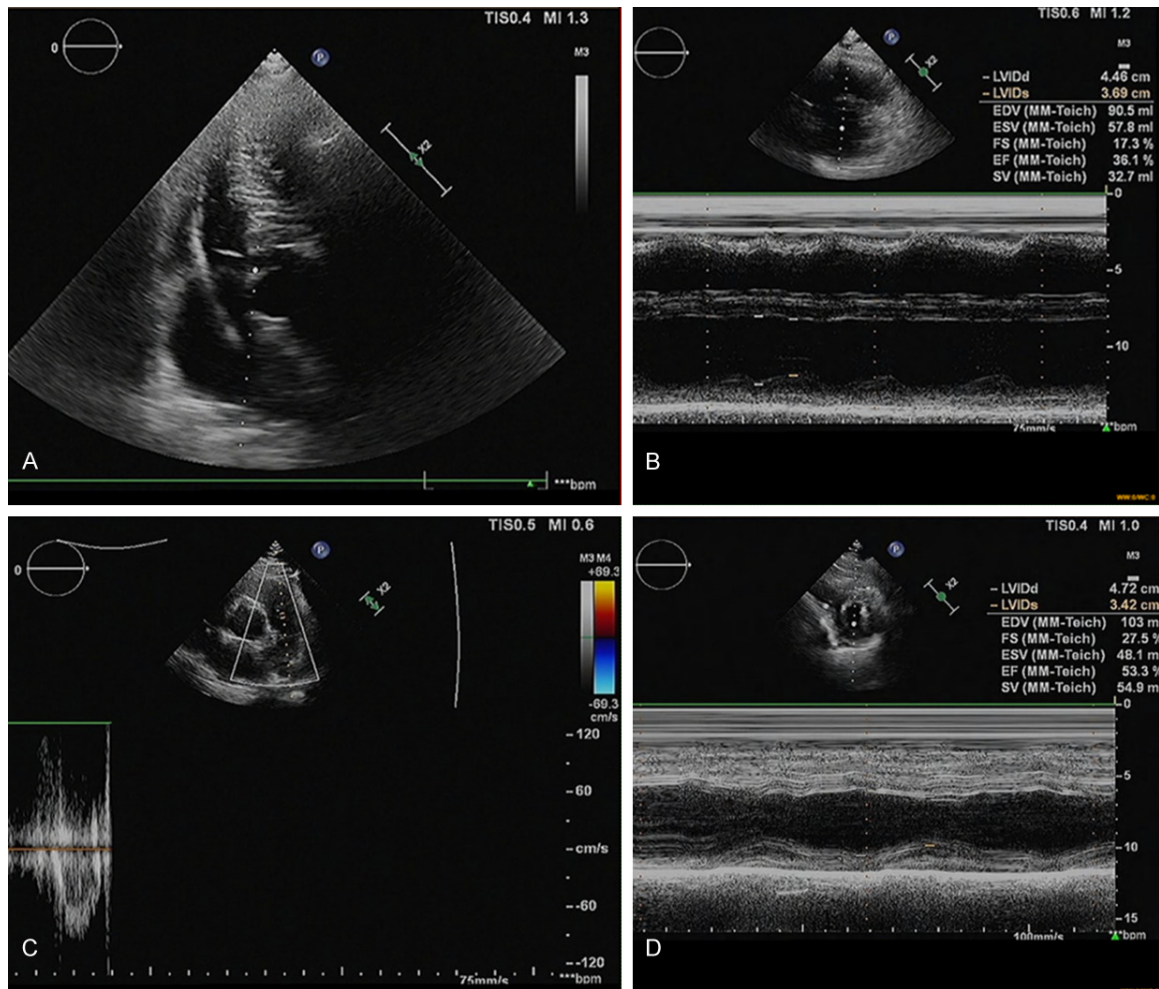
Representative echocardiographic images. A, B. Before treatment; C, D. After treatment.
